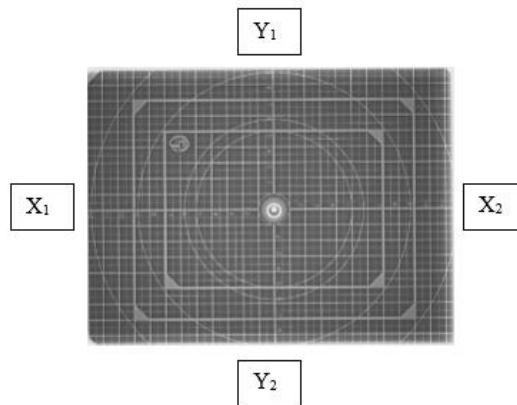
Radiographic image of the third test result (FFD 130 cm)
